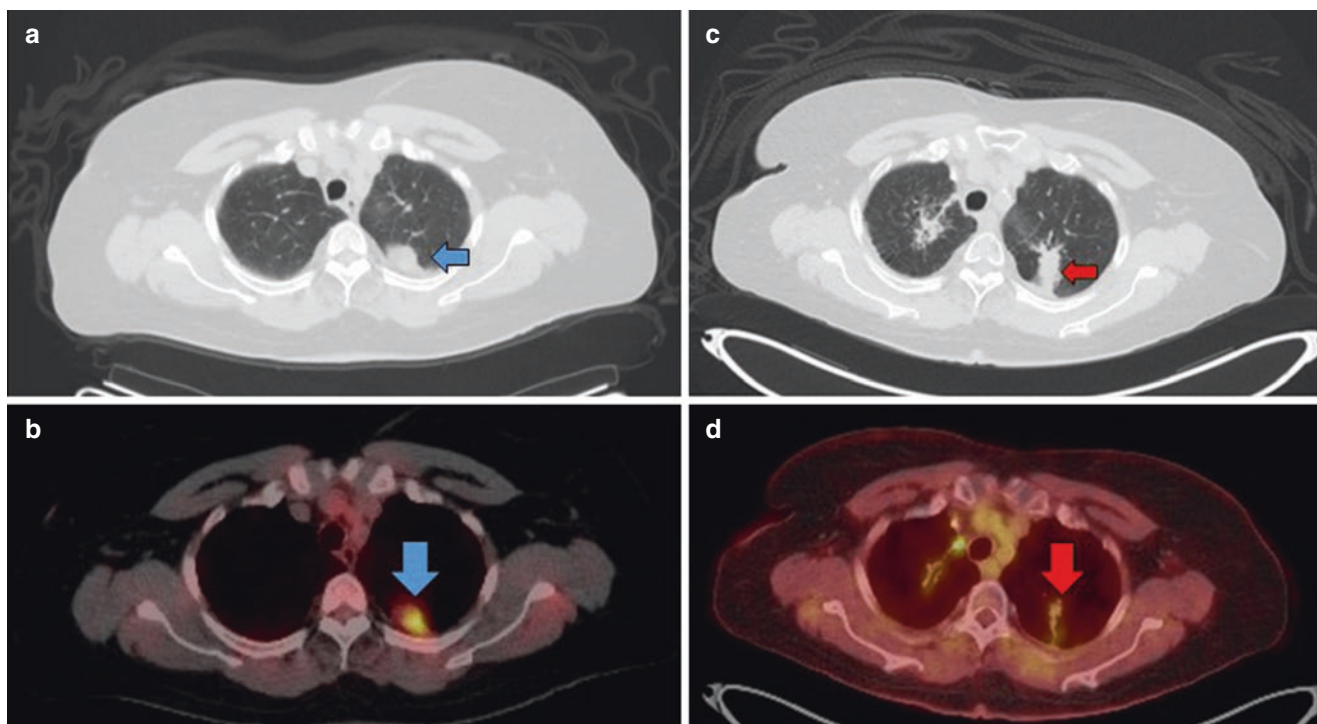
(a–d) Representative axial FDG-PET CT images from a 68-year-old female with medically inoperable, early-stage squamous cell carcinoma of the left upper lobe of the lung, following lung SBRT
